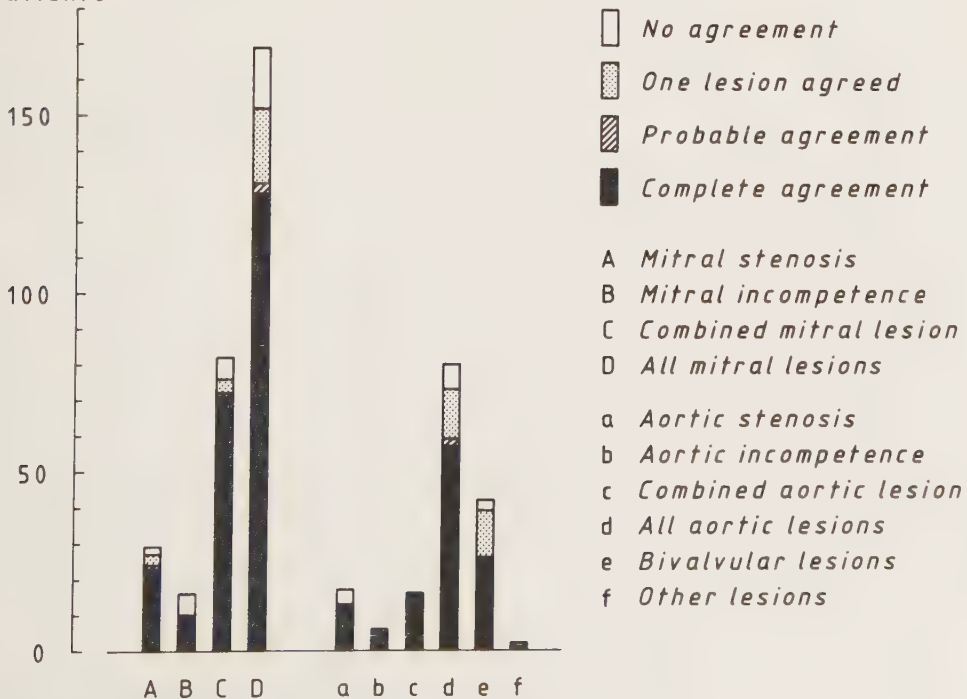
Agreement between clinical and roentgen findings.
